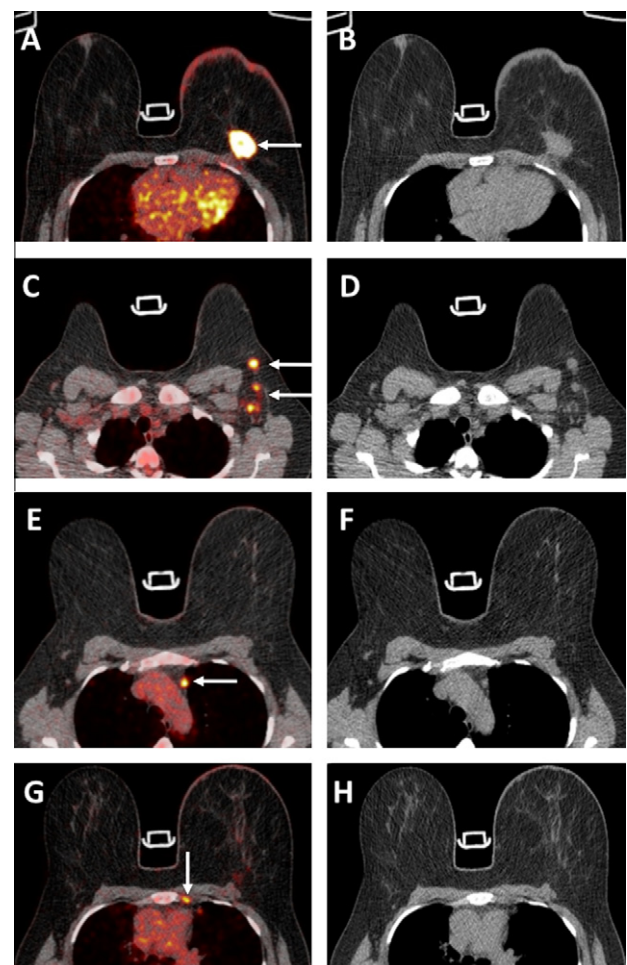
Patient with a FDG-avid carcinoma of the left breast seen on FDG PET/CT fusion (arrow on A) and corresponding CT (B) transversal images. FDG PET/CT (C) shows three hot spots in the left axilla (arrows) corresponding with some enlarged lymph nodes on CT (D). In this patient PET-CT detected also lymph node metastases (arrows) in the mediastinal area (E and F) and in one of the intercostal spaces (G, H).
